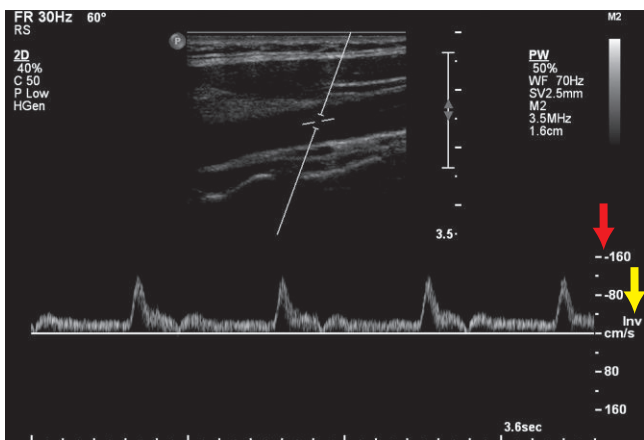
Spectral Doppler of common carotid artery has flow away from the transducer. The spectrum is ABOVE the baseline because the spectrum has been inverted. Note the Doppler shifts are in the negative range above the baseline (red arrow) and the spectral is labeled Inv for inverted (yellow arrow).
